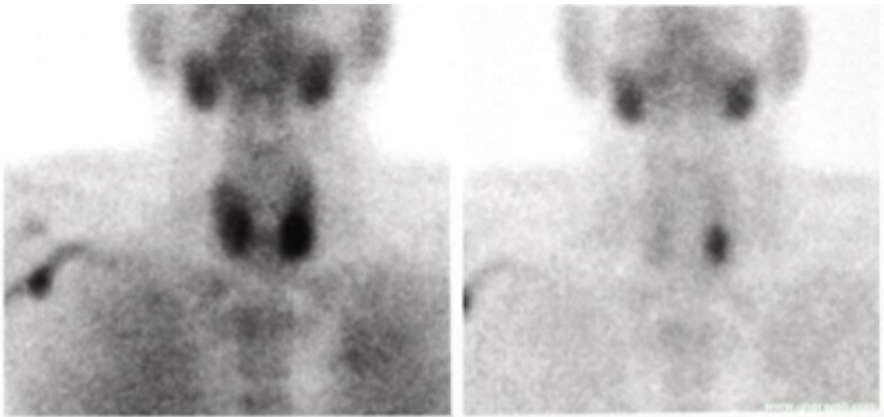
Single-isotope scintigraphy:
